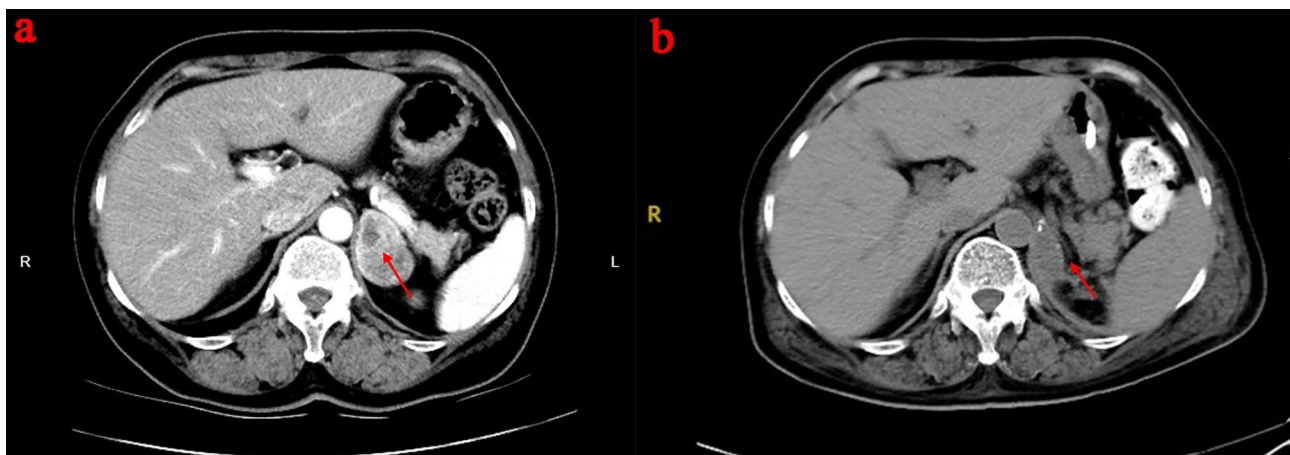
(a) Preoperative abdominal CT image. The marked area is pheochromocytoma (b) Postoperative abdominal CT image. The marked area is after tumor resection
